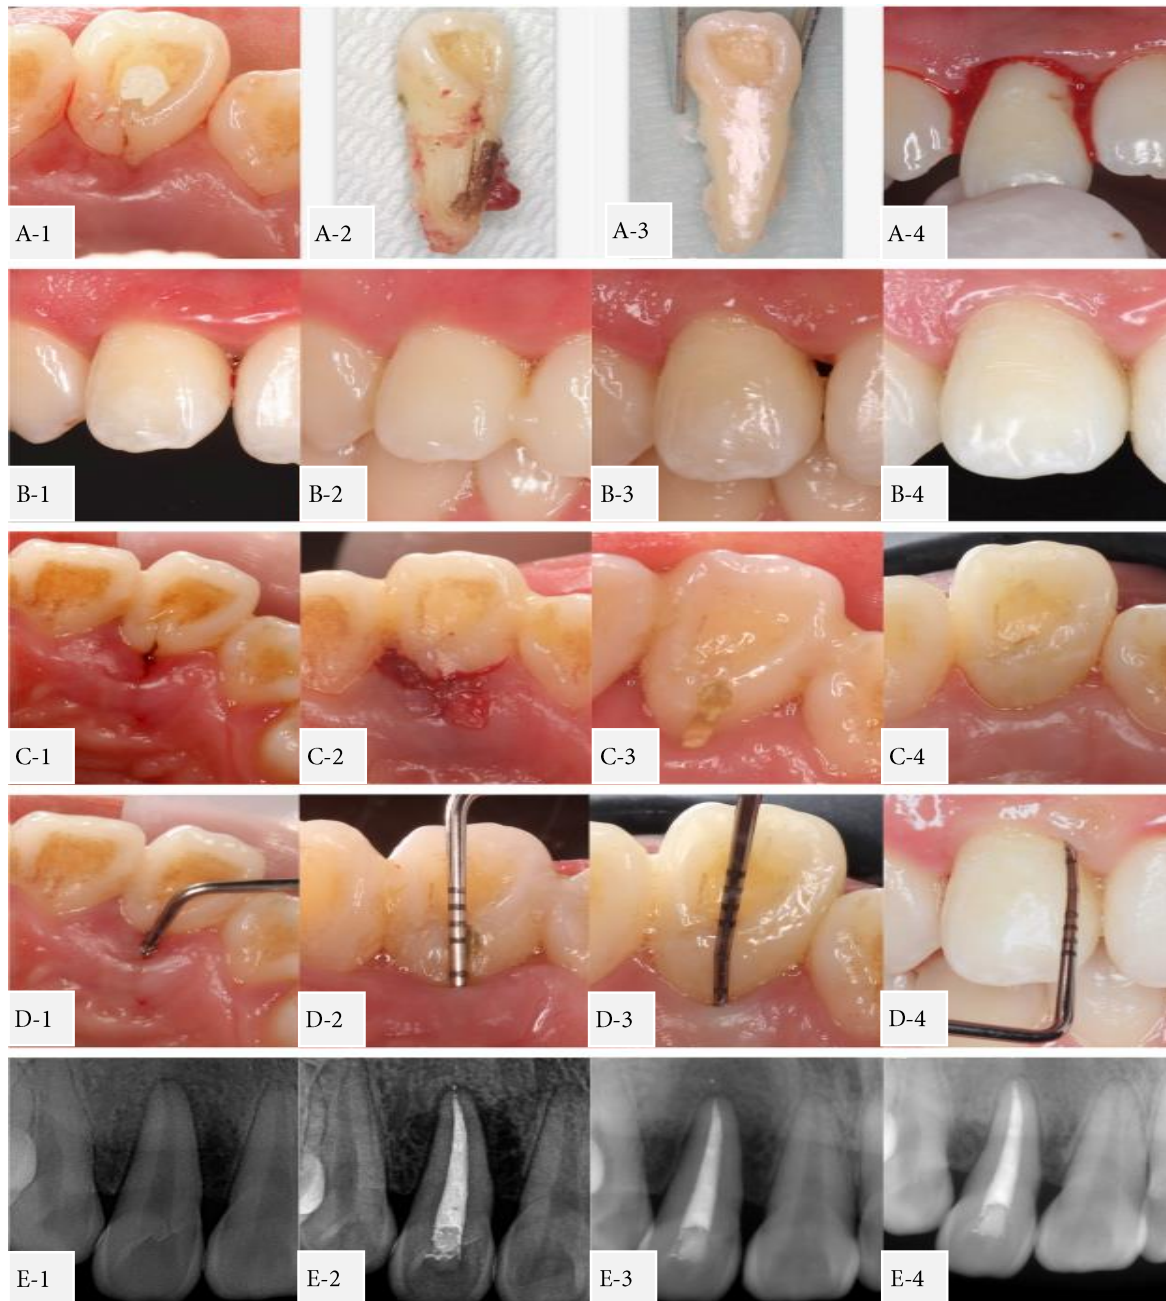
A-1) Coronal photographic view of lateral incisor after root canal therapy; A-2) Upper lateral incisor after extraction; a deep palatal radicular groove was found up to 1/3 of the apex, with deposit of dental calculus and granulation tissue in and around the groove after extracting; A-3) IRoot BP Plus was applied to seal the whole groove after cleanup; A-4) The tooth was replanted back to the socket; B-1) Labial view of the gingival papilla at the initial visit; B-2) Appearance of gingival papilla two weeks post intentional replantation (IR); B-3) The interproximal papilla receded with a marked black triangle 6-month after IR; B-4) Labial view showing gingival papilla has completely filled the inter-proximal embrasure 2-year after intentional implantation; C-1) The gingival papilla appearance was red and swollen on palatally on the first visit; C-2) Palatal view of the gingival papilla immediate post-operation; C-3) Two weeks post IR, the color and texture of palatal periodontal tissues recovered to stippled pink; C-4) Palatally, the gingival papilla completely filled the inter-proximal embrasure 2-years after intentional implantation; D-1) The probing depth was 10 mm palatally before surgical operation; D-2) The probing depth was 4 mm at palatal site 6-month after IR; D-3) Two years after intentional implantation, probing depth was 2 mm in the palatal gingivae; D-4) Labial at two years post op, probing depth was 2 mm ; E-1) Periapical radiograph shows decreased alveolar bone density mesial of the lateral incisor in the initial visit; E-2) The radiographic evaluation of tooth after root canal treatment; E-3) The radiographic evaluation of tooth showed increased bone density 6-month post operatively; E-4) No ankylosis or external root resorption of the tooth was found in the final periapical radiograph 2-year after IR
